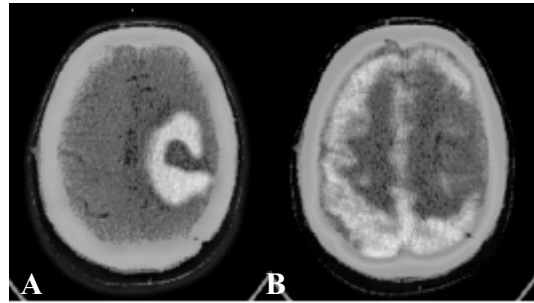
A post-operative case of recurrent glioma. Lesion delineation is superior on F-DOPA PET/CT image (A) compared to the FDG PET/CT image (B).
